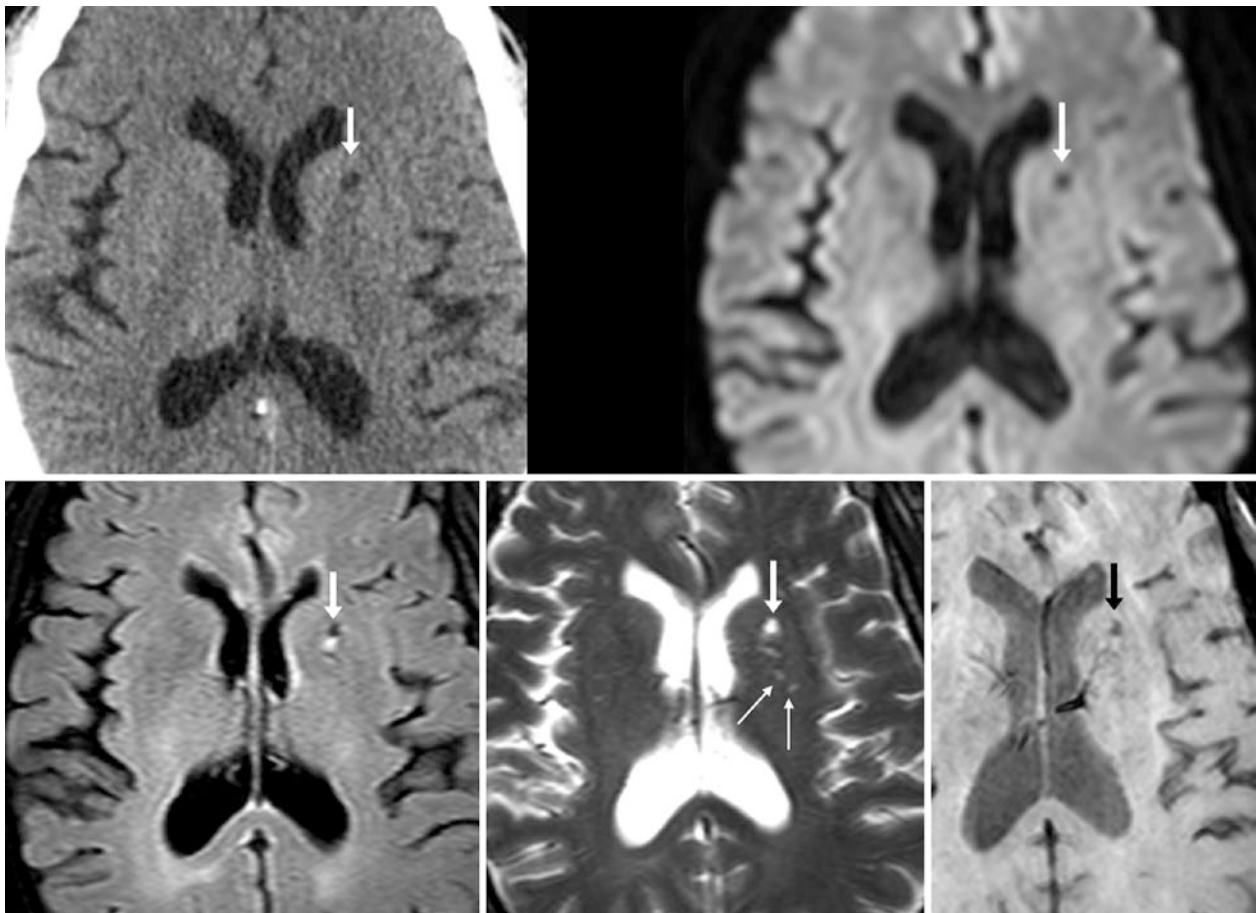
Comparison case of lacunar infarct. A 54 year old had a lacune (dashed arrows) identified on NECT (top left), as its density was greater than that of the CSF. On MRI it was dark on DWI MRI (top right), bright on FLAIR (bottom left), and had CSF-like signal on T2WI
